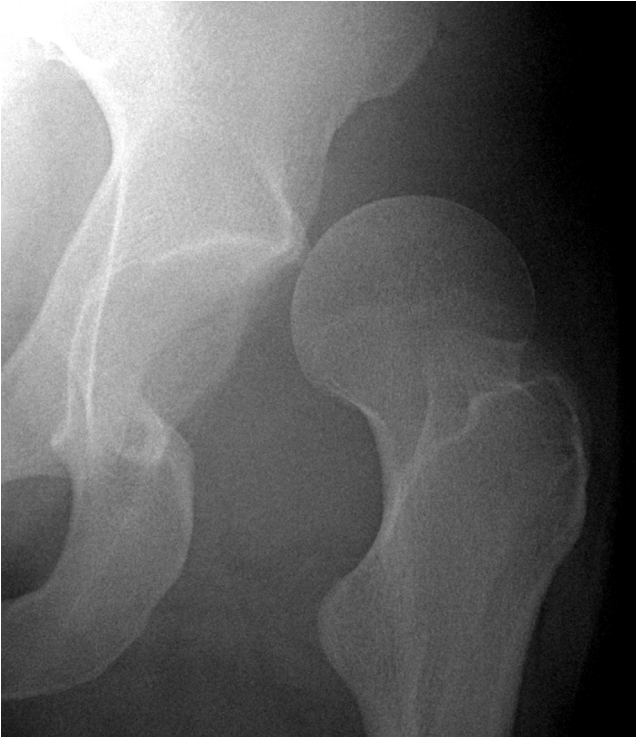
Anteroposterior radiograph showing anterior dislocation of left hip.
